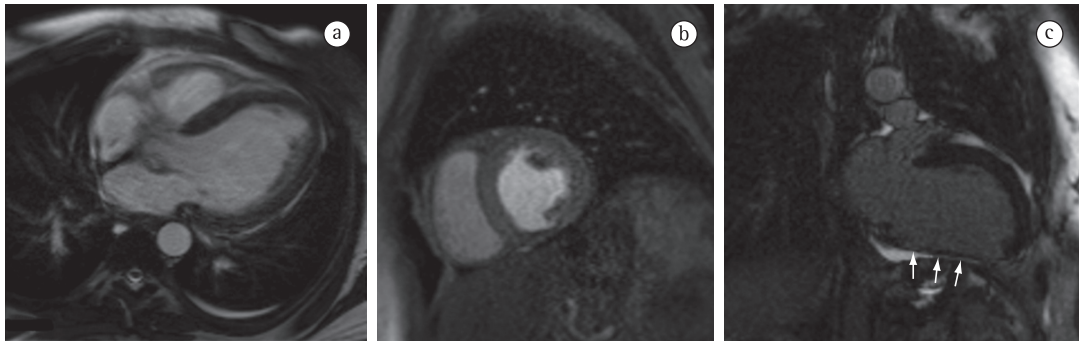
True fast imaging with steady-state precession cardiac magnetic resonance image (a) of the long axis of the left ventricle (LV), used for morphological and functional evaluation; dynamic contrast-enhanced gradient-echo sequence image of the short axis of the LV (b), used for the study of myocardial perfusion; delayed contrast-enhanced myocardial signal suppression sequence image of the vertical long axis of the LV (c), which allows the evaluation of myocardial viability. On the perfusion and viability images, we can identify old infarction of the inferior left ventricular wall, with tapering and contrast enhancement due to fibrosis (arrows in c).
